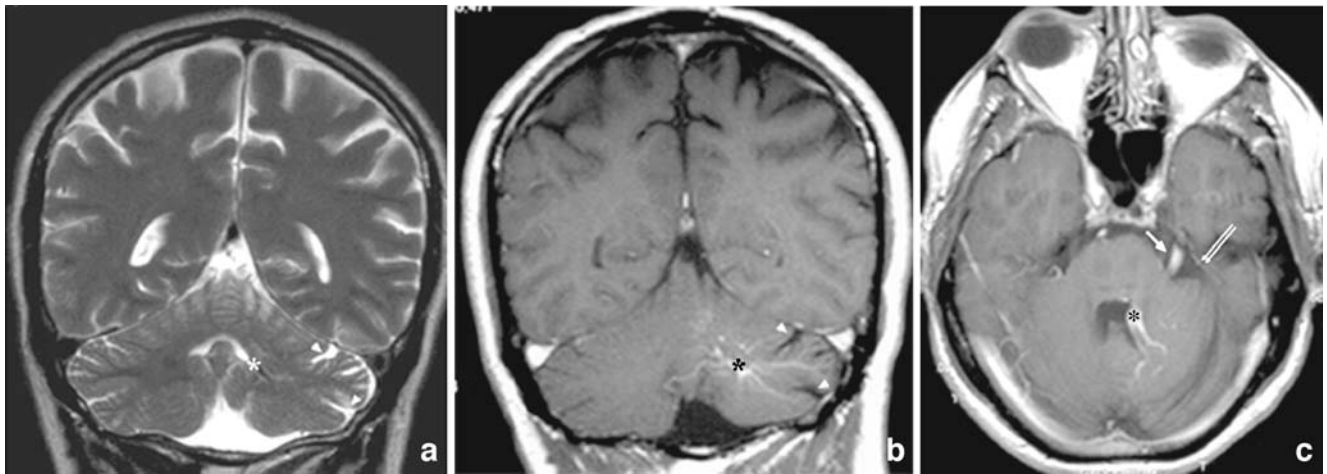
Thirty-year-old male with multiple sclerosis. a, b Standard fast-spin echo T2-weighted (T2-W) and post-contrast Gadovist injected three-dimensional T1-weighted (Gd 3D T1-W) coronal views showing a large, left vermian and hemispheric cerebellar DVA (*asterisk*) with cortical cerebellar atrophy (*arrowheads*) within the drainage territory of the developmental venous anomaly (DVA). The DVA collecting vein appears as a flow void on the T2-W image. The left cerebral
